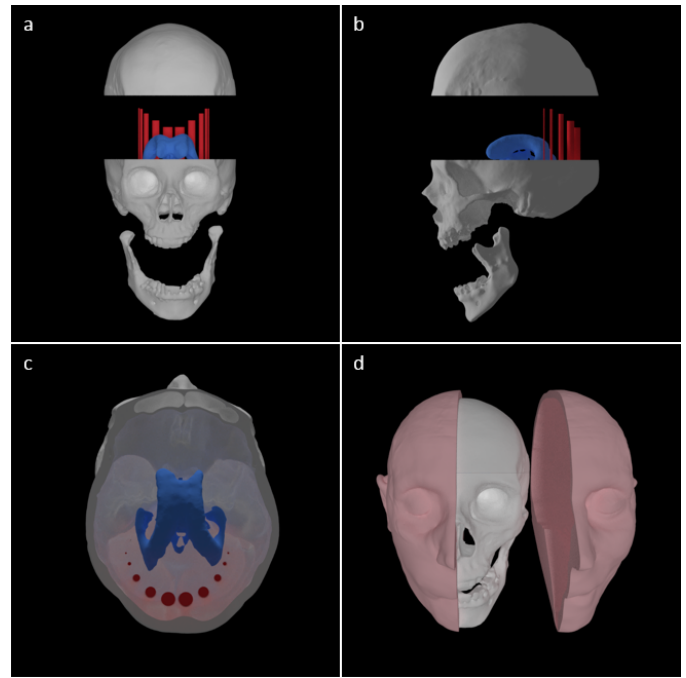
CBCT data based design a) anterior-posterior view of the skull mesh, containing inserts (red) and ventricles containing cerebrospinal fluid (blue). b) left lateral view of the skull mesh c) axial superior-inferior view of the skull mesh (no calvaria) with the low contrast inserts at the posterior side of the skull (red) and the ventricles (blue). d) vertically cut muscle shell mesh, surrounding the skull mesh.
